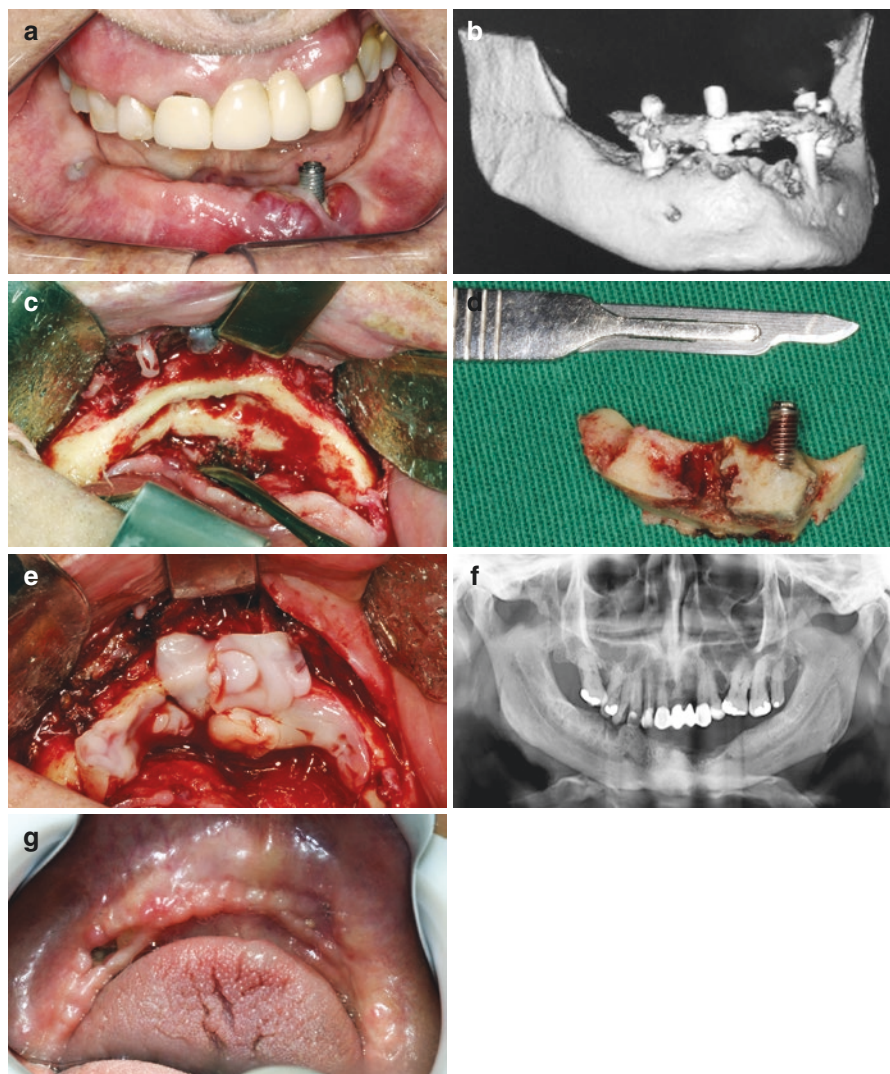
(a) Patient who was started in intravenous bisphosphonates for cancer treatment 2 years after oral rehabilitation with dental implants. He was evaluated after spontaneous loss of two implants, with pain and local infection. (b) Cone-beam CT scan compatible with osteonecrosis. (c) Removal of necrotic bone and implants. (d) Removed bone segment. (e) Covering of viable bone with leucocyte platelet-rich fibrin. (f) Postoperative radiograph after 45 days. (g) Healing of mucosa after 45 days
